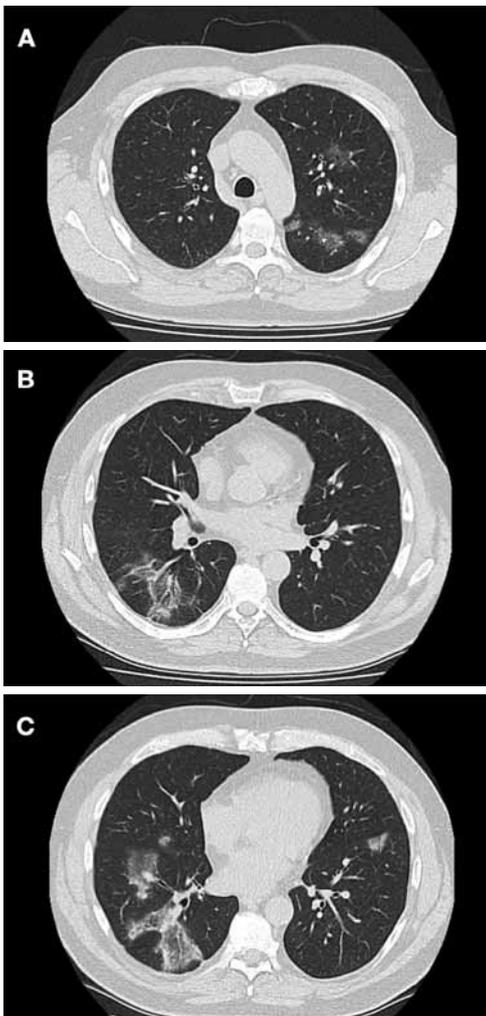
Transverse axial CT images of the patient's chest from May 2018. Ongoing evolution of consolidation and central ground glass opacity can be seen in the left upper lobe (A). A wider area of parenchymal involvement can also be seen in the right lower lobe (B). The regions of consolidation in the right lower lobe (C) appear to have more ground glass opacification.
